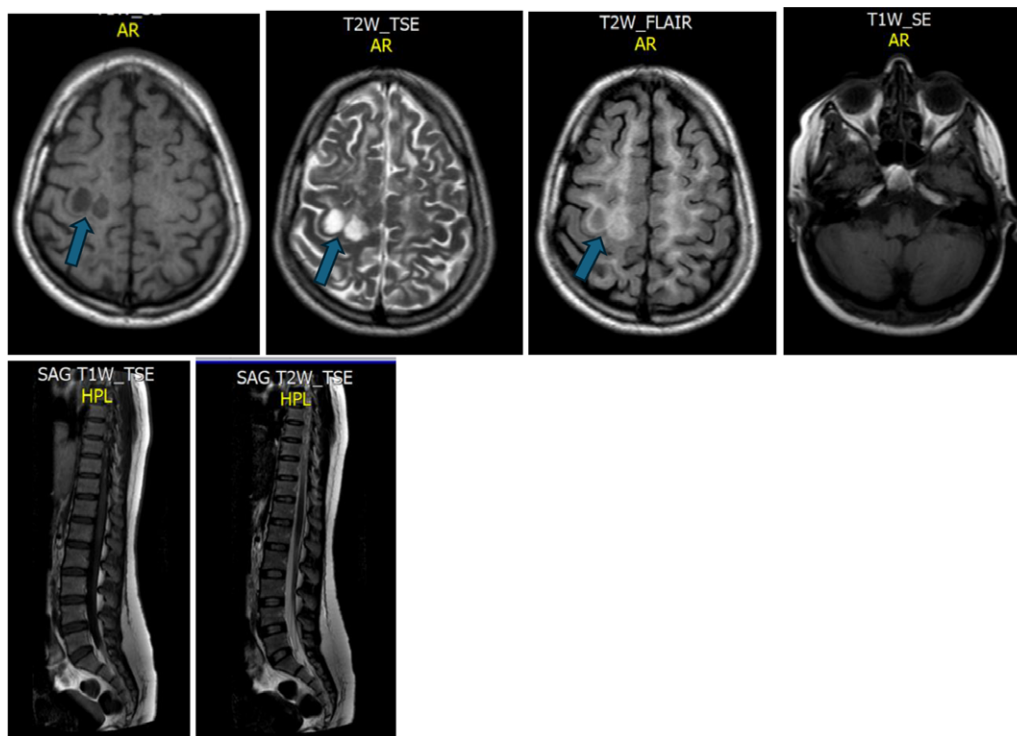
The brain and whole spine MRI in November 2022 showed two periventricular hyperintense lesions on T2-weighted Imaging (T2WI) and two hypointense lesions on T1-weighted Imaging (T1WI); these lesions are typical for demyelination (blue arrows). Regarding the sagittal lower lumbar and dorsal spine MRI, the T1WI and T2WI showed no signal abnormality in the visualized lower cord or conus medullaris.
